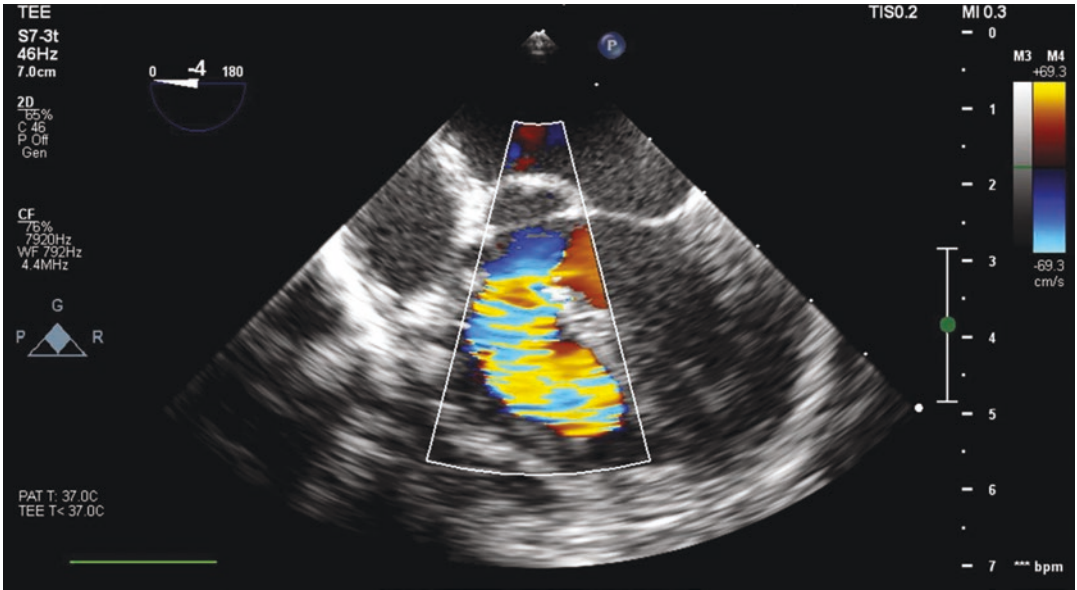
Preoperative TEE 4 chamber view, similar to Fig. 2, with the addition of color Doppler mapping, demonstrating left to right VSD flow
